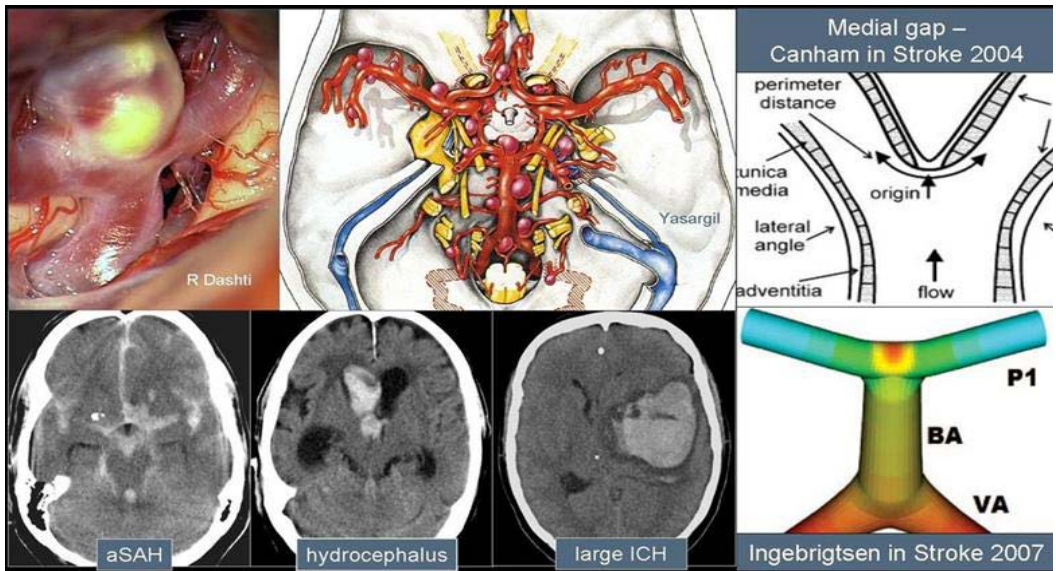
Saccular intracranial aneurysm (sIA) and subarachnoid hemorrhage (aSAH). Upper row from left to right. Unruptured sIA in the bifurcation of the internal carotid artery. The Circle of Willis connecting the intracranial extracerebral arteries with sIAs in the main branching sites. The medial gap area in the bifurcation. Lower row from left to right. Typical acute aSAH in computed tomography (CT), blood in the CSF spaces appearing white. Acute aSAH with intraventricular hemorrhage and acute hydrocephalus. Acute aSAH with large intracerebral hemorrhage. Hemodynamic model of basilar artery bifurcation area.
